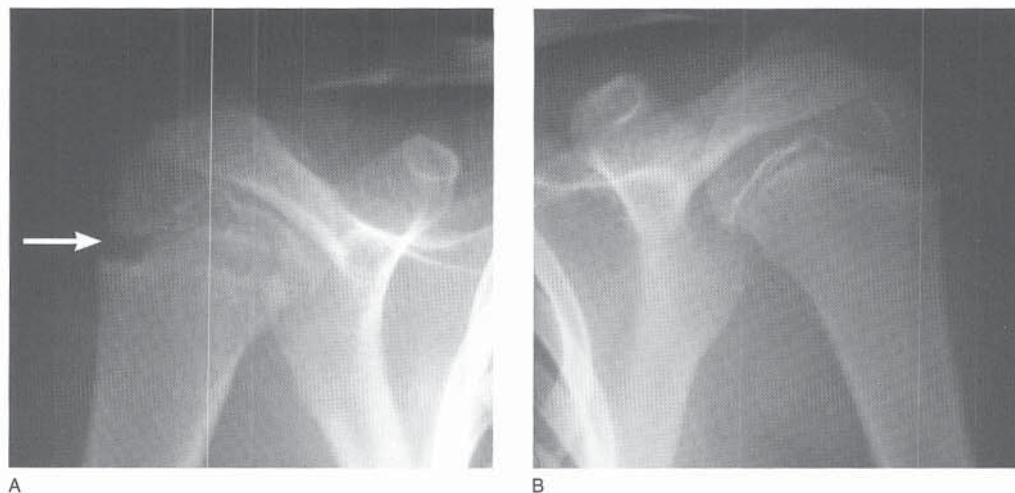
A and B, AP radiographs of both shoulders in an adolescent baseball player. Note the widened right proximal humeral epiphysis (arrow in A).
